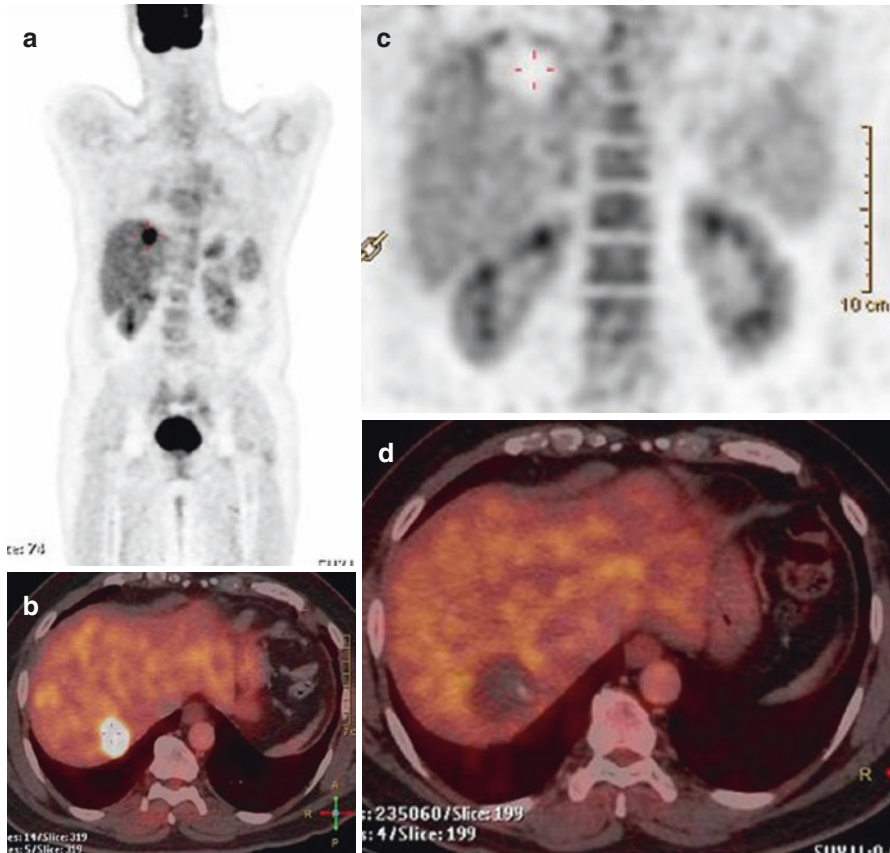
Hepatic metastasis in a case of colon carcinoma, FDG PET/CT study done for restaging revealed a solitary liver lesion as seen in the whole body maximum intensity projection (MIP) (a) and well appreciated on the fused transaxial image (b). Post RFA FDG PET/CT study shows a photopenic area on the coronal PET image (c) which corresponds to the site of lesion with no uptake within or in the periphery as seen in the fused image (d) depicting completeness of the procedure
